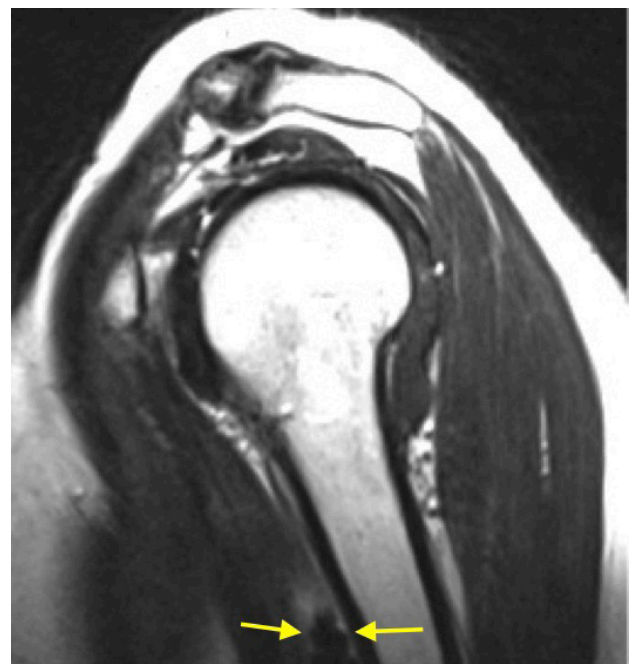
Sagittal oblique T2 weighted MR image of the shoulder demonstrating the calcific lesion within the biceps tendon sheath (arrows).
